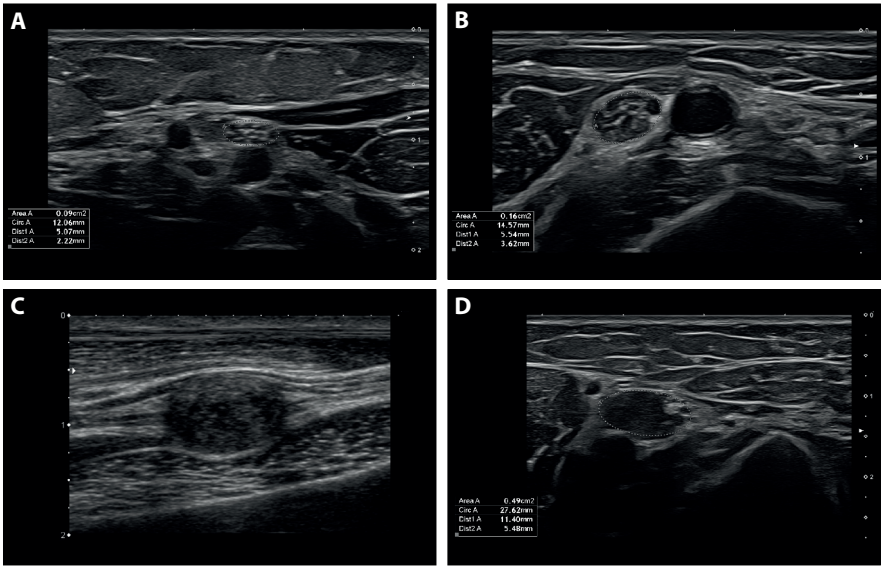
shows images of the median nerve in the arm obtained by nerve ultrasound. 2A Transversal image of a median nerve of a healthy control with a characteristic 'honeycomb' structure (cross-sectional area (CSA) 9mm²). 2B Transversal image of a median nerve in a patient with multifocal motor neuropathy (MMN) with increased nerve CSA and fascicle size (CSA 16mm²). 2C Longitudinal image of a median nerve in a patient with neurofibromatosis type 2 showing a schwannoma. 2D Transverse image of a median nerve in a patient with neurofibromatosis type 1 showing a plexiform neurofibroma (CSA 49mm²).
